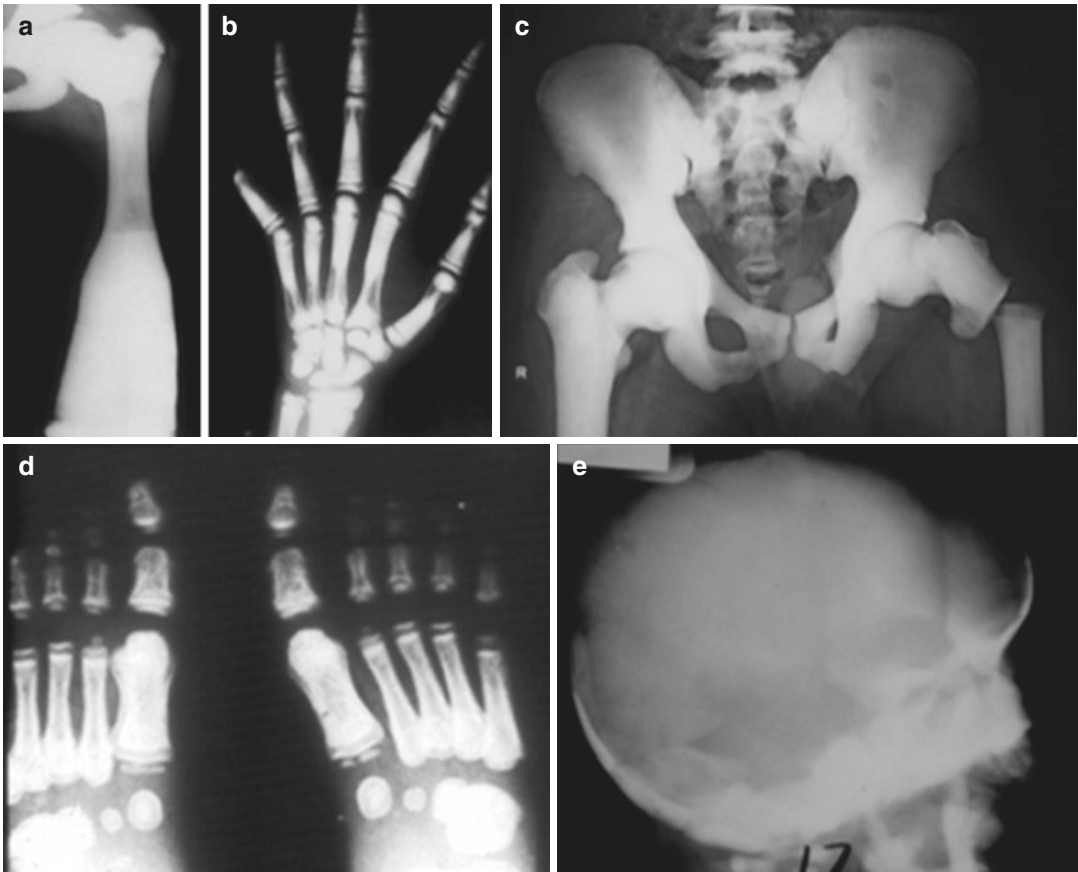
Osteopetrosis. (a) Frontal radiograph of the femur shows osteosclerosis with abnormal distal metaphyseal remodeling resulting in the “Erlenmeyer flask” deformity. (b) Frontal hand radiograph shows the “bone-within-a-bone” appearance (endobones) along with increased bone density. (c) Frontal radiograph of the pelvis shows osteosclerosis with obliteration of the trabeculae
